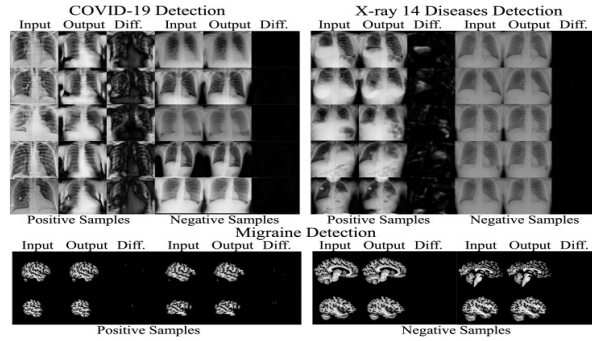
MedAI AnomalyPro’s results for detecting COVID-19, Chest X-ray 14 illnesses, and migraines
